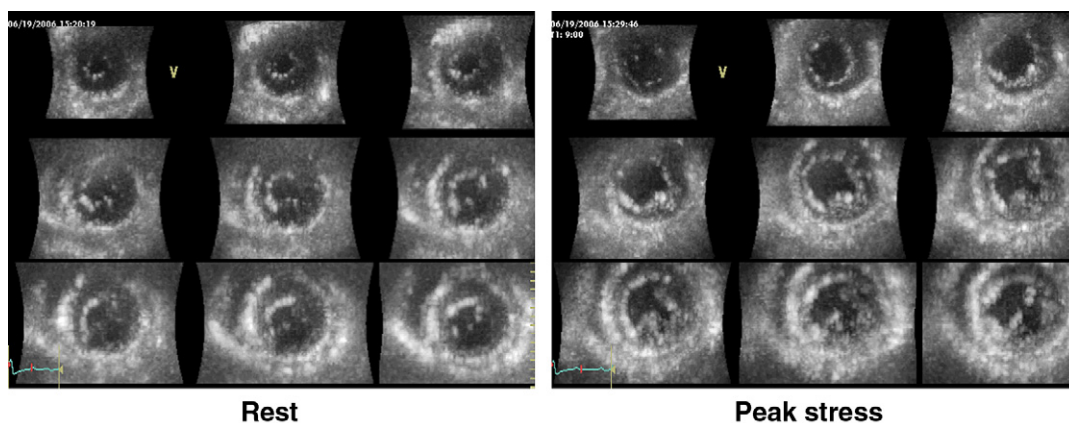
Multiple 2D short-axis views (nine-slice) from full-volume datasets during dobutamine stress echocardiography. By cropping full-volume datasets, multiple 2D short-axis views from apex to the basal part of the heart can be obtained. These short-axis views obtained at end-systolic frame clearly show cavity dilatation at peak stress (*right panel*), suggesting the presence of multivessel disease. Coronary angiography confirmed the presence of triple vessel disease.
